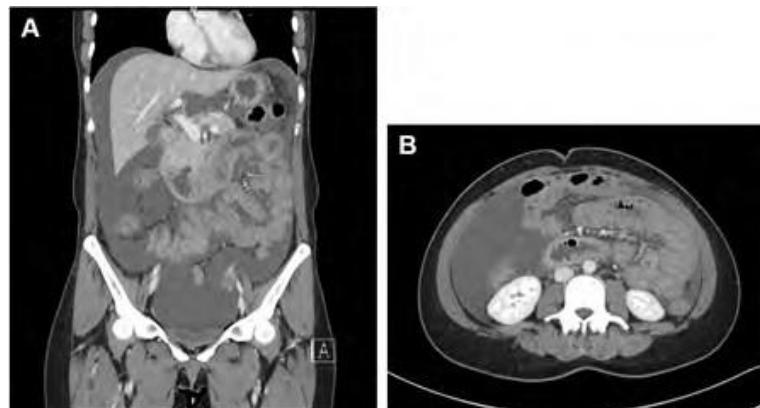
Abdominopelvic CT (A, transverse view; B, coronal view) Long segmental edematous wall thickening of stomach~colon. Large amount of fluid collection in subhepatic&pelvic cavity with mesenteric infiltration.
